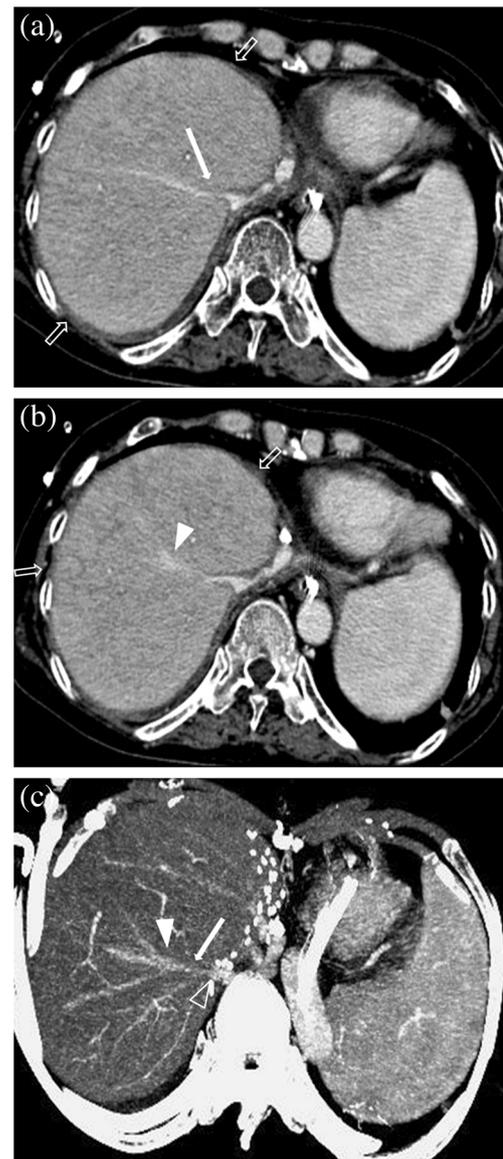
Images from a 51-year-old woman (initial RAI 8) who underwent right lobe LDLT for primary biliary cirrhosis. On portal venous-phase CT axial images (a, b) performed 35 days after LT, liver graft showed severe globular swelling presenting obtuse angles between any sets of the graft margins (empty arrows), short segmental nonanastomotic luminal narrowing of the right hepatic vein (arrow) with prestenotic dilatation (arrowhead), and diffuse heterogeneous enhancement. c On axial maximum intensity projection (MIP) image, short segmental nonanastomotic luminal narrowing of the right hepatic vein (arrow) with prestenotic dilatation (arrowhead) was noted. Anastomosis between right hepatic vein and IVC was marked (empty arrowhead)
